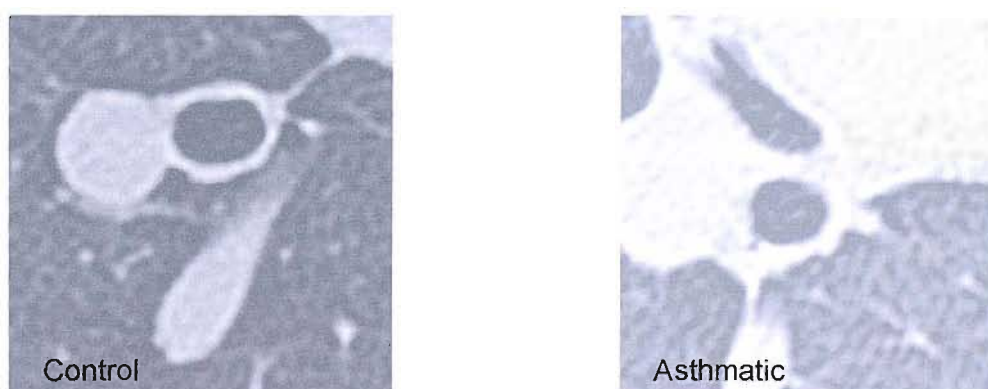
Examples of HRCT airway images from a control and asthmatic subject
